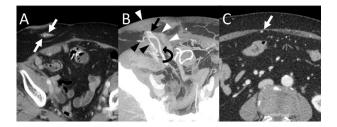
(A) Contrast-enhanced CT shows ileal conduit stomal varices (white arrows). (B) Maximum intensity projection image of portal-phase contrast-enhanced CT demonstrates varices (black arrow) in the ileal conduit stoma (white arrowheads). A feeding ileal vein (black curved arrow) and two draining veins (black arrowheads) are visible. (C) Contrast-enhanced CT shows a deep and small paraumbilical vein (white arrow). At this level, the vein was punctured with ultrasound guidance.
